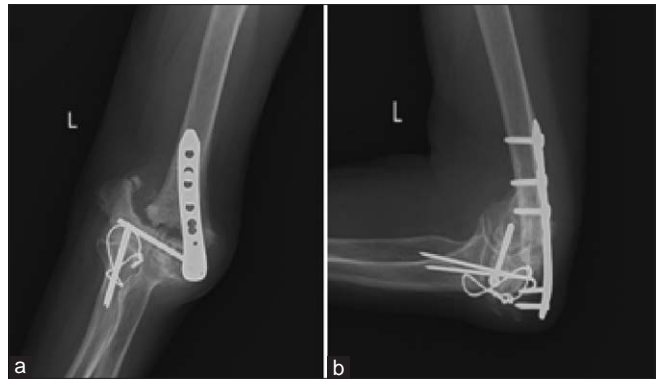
Preoperative plain radiograph showing nonunited distal humeral fracture with implants *in situ*. (a) Anteroposterior view; (b) Lateral view
